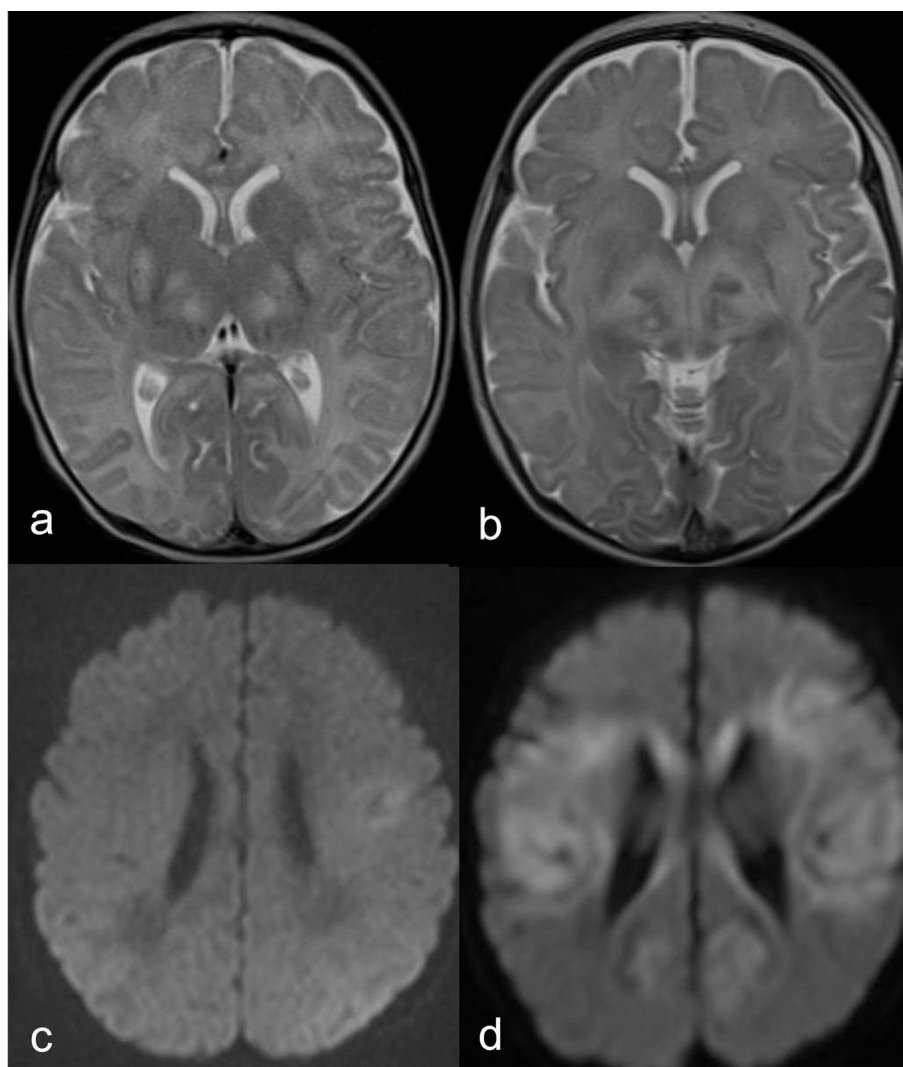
Axial T2-weighted MR images (a, b) and DWI (c, d) show increased signal intensity in the putamina and bilaterally frontal and parietal lobe. 2-week after (b, d) treatment with thiamin and biotin, swelling and abnormal hyperintense areas reveal progression.
